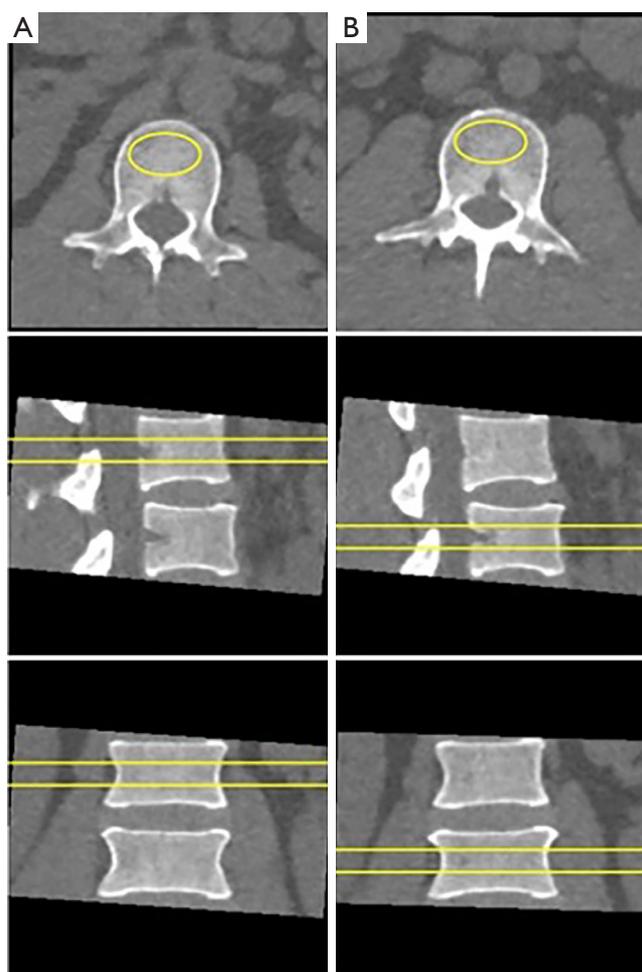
QCT measurement of L1 (A) and L2 (B) lumbar spine BMD. The dual-yellow lines indicate the location and upper and lower range of interest (region of interest, ROI), the yellow oval ROIs show the measurement range of vertebral, and the BMD unit is mg/cm³. QCT, quantitative computed tomography; BMD, bone mineral density.
